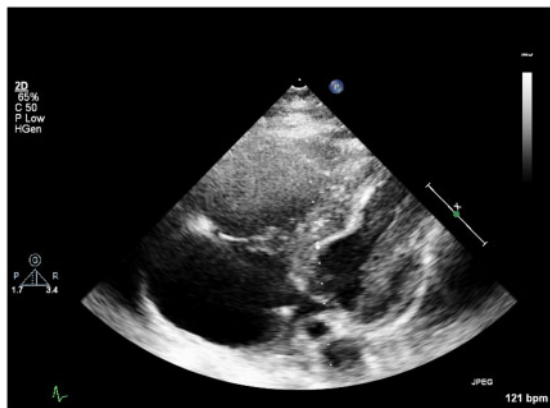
Bedside echocardiogram with subcostal view showing severe right ventricular enlargement.
